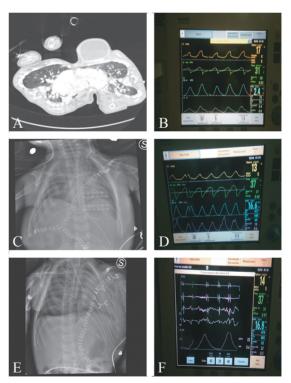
Use of postoperative invasive and non-invasive NAVA ventilation on the two separated twins: A) preoperative CT image; B) sister 1 NAVA setting for invasive ventilation; C) chest X-ray image during sister 2 Helmet NAVA non-invasive ventilation; D) sister 1 NAVA non-invasive ventilation setting; E) chest X-ray during sister 1 Helmet NAVA non-invasive ventilation; F) sister 1 NAVA non-invasive ventilation Edi catheter positioning.
